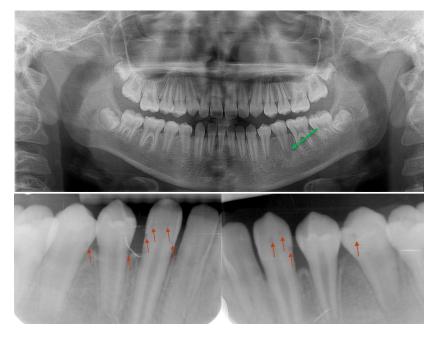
Radiographic images obtained during the initial clinical assessment of our patient with tuberous sclerosis complex. Tooth 35 demonstrates an open apex and radiolucent apical lesion (green arrow), while periapical films reveal multiple radiolucent images corresponding to dental enamel pits (red arrows).
